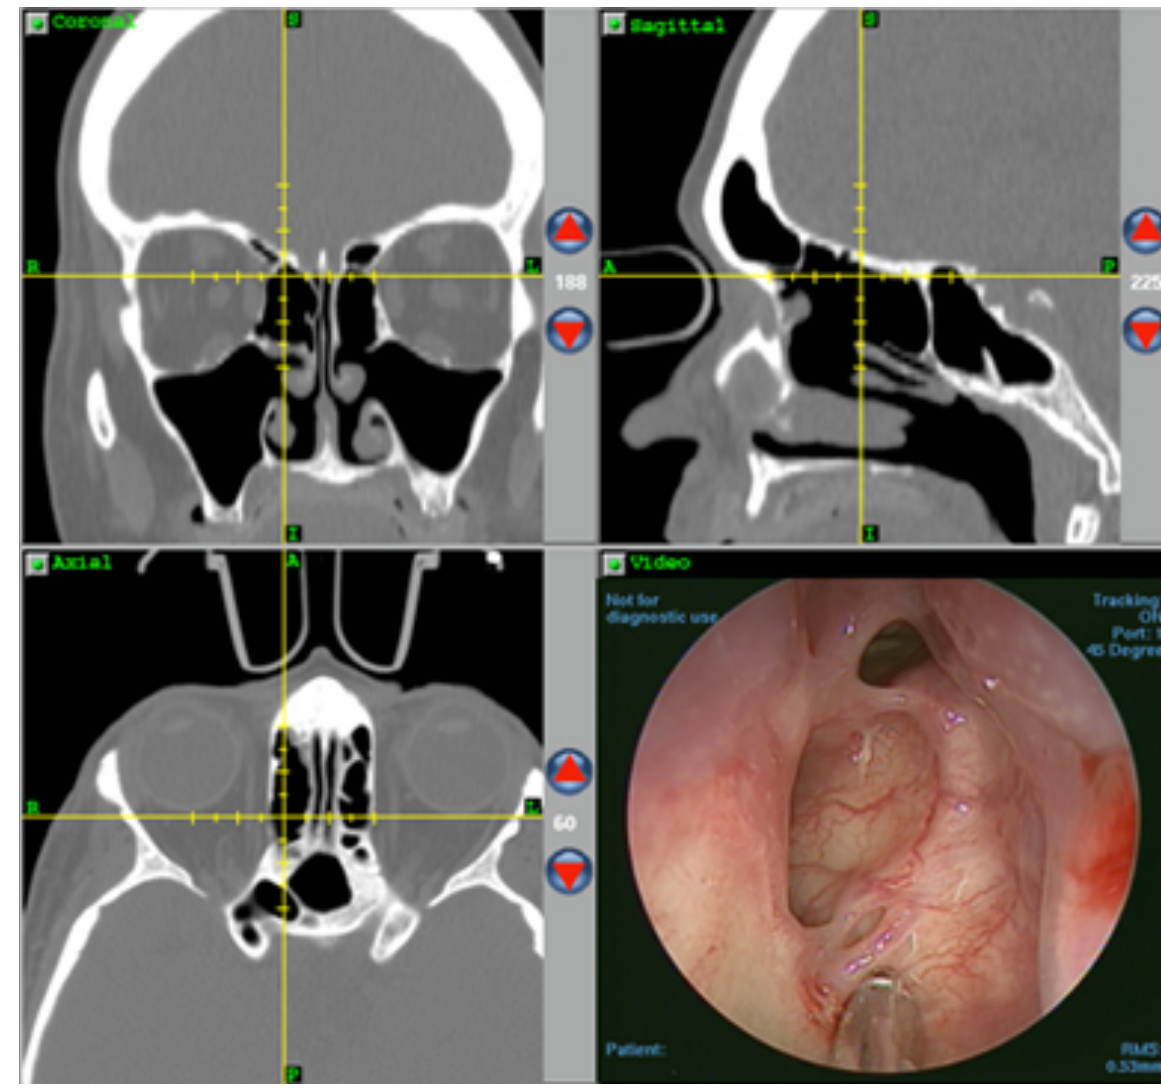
Visualization of the sinuses on a preoperative CT scan in the (top left) coronal (top right) sagittal (bottom left) and axial planes. The surgeon correlates these images with the pictures from an endoscopic camera (bottom right). [Adopted from <http://www.arizonasinus.com/image-guided-endoscopic-surgery.htm>]
